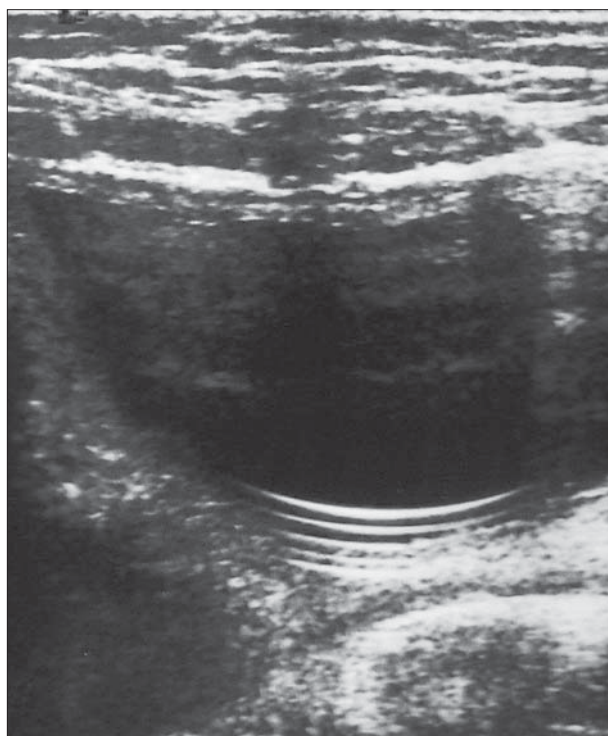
Ultrasonographic imaging of the pelvis with VP catheter in the urinary bladder lumen
